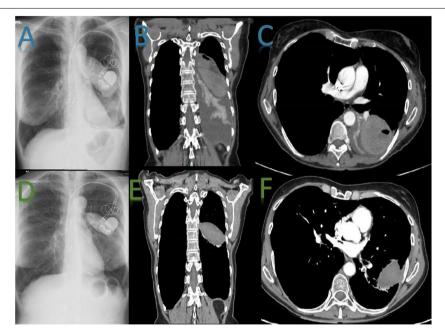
(A) Chest X-ray: mild impingement of the right costophrenic sinus, suggestive of left pleural effusion, along with homogeneous opacity in the left mid-lung field. (B) Thorax computer tomography (CT): intracisural image suggestive of hematoma due to its homogeneity and attenuation, confirming the presence of left pleural effusion and atelectasis of the left lower lobe. (C) Axial image, thorax CT: intracisural image suggestive of hematoma due to its homogeneity and attenuation, confirming the presence of left pleural effusion and atelectasis of the left lower lobe. (D) Chest X-ray: reduction of hematoma size and resolution of the previously observed pleural effusion in the left area, with normalization of the corresponding costophrenic space. (E) Thorax CT: notable reduction in the size and extent of the previously identified intracisural hematoma. The attenuation of the hematoma has significantly improved, indicating partial resolution. The disappearance of atelectasis in the left lower lobe is confirmed, with complete expansion of pulmonary structures in that region. There is no evidence of pleural effusion on the CT scan, suggesting complete resolution of this finding. (F) Axial image, thorax CT: reduction of hematoma size, disappearance of effusion and absence of atelectasis. Notable improvement compared to previous studies.
